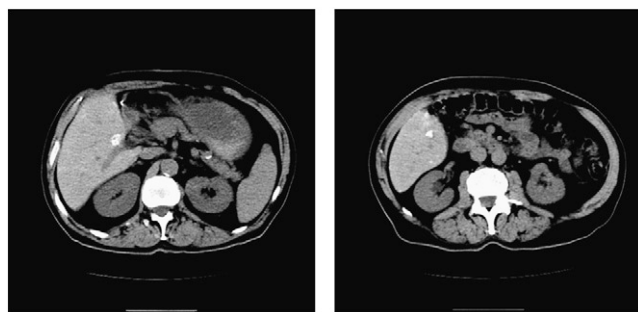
CT scans of 2 patients showing slight ^{131}I -lipiodol retention 7 d after ^{131}I -lipiodol injection.
